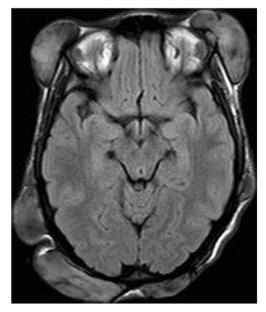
Patient 2, 23-year-old woman. T1-weighted axial MR scan shows multiple nodules in the scalp
